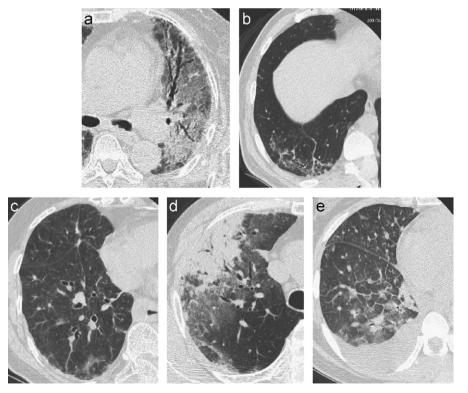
Representative high-resolution computed tomography (HRCT) patterns: (a) diffuse alveolar damage (DAD) pattern, (b) non-specific interstitial pneumonia (NSIP) pattern, (c) hypersensitivity pneumonitis (HP) pattern, (d) organizing pneumonia (OP) pattern, and (e) acute eosinophilic pneumonia (AEP) pattern.
